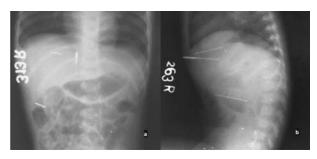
Plain abdominal antero-posterior (a) and lateral (b) abdominal radiograph showing needles in abdominal cavity.
